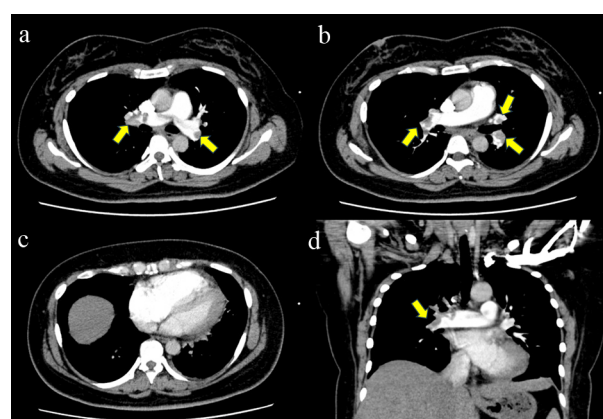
Contrast-enhanced chest computed tomography on admission
